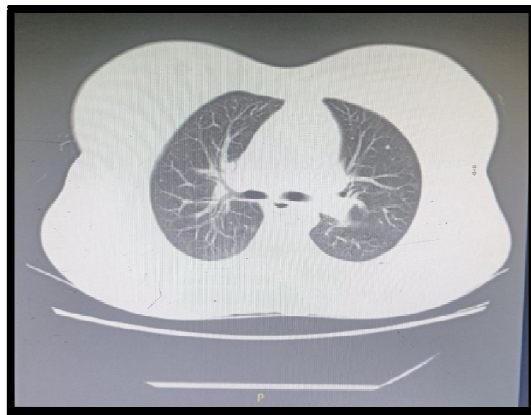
CT Chest – B/L Consolidation with minimal effusion in base of lower lobe
